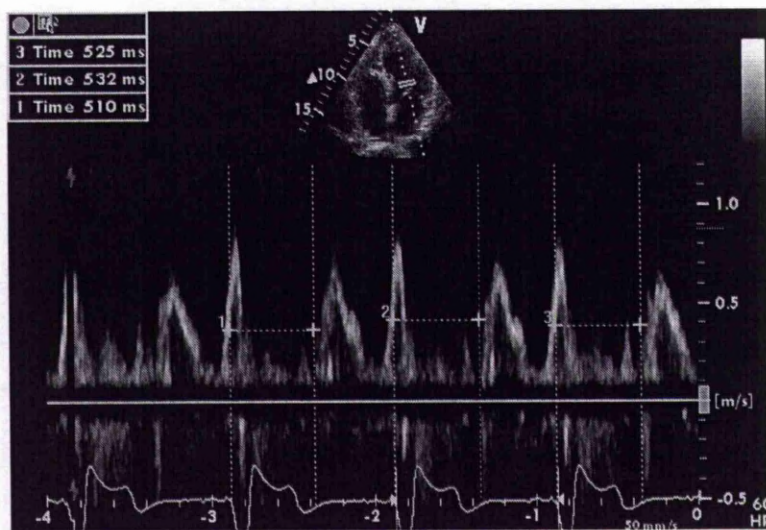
D2 measurement. It is the distance between the start of the QRS to the beginning of E wave on pulse wave Doppler (mean value 523 msec).
